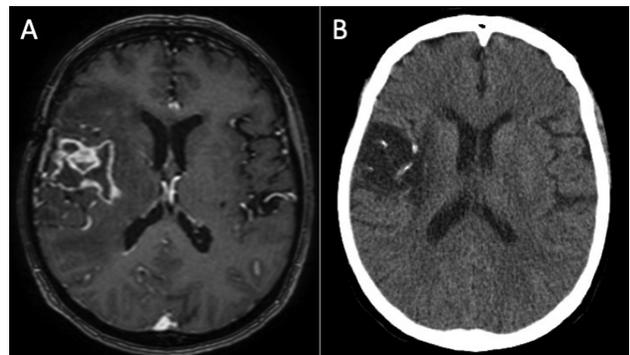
(A) Magnetic resonance imaging of the brain in axial section in T1-weighted sequence with the presence of an expansive lesion with hypointensity and predominantly annular enhancement by gadolinium. (B) Computed tomography of the skull in axial section at the same level. Note non-specific hypodensity associated with intralesional bleeding.
